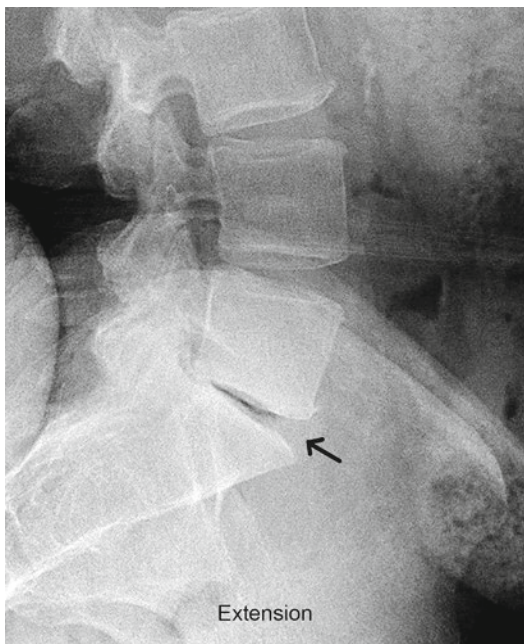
Extension radiograph demonstrates the disc space narrowing, anterior osteophyte formation (*arrow*)
